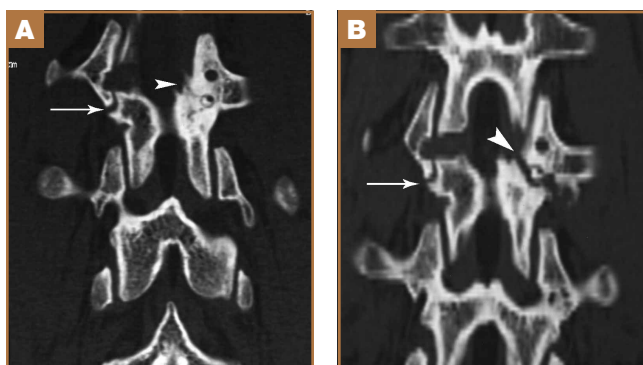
(A) Follow-up CT images 3 weeks after second RFA show minimally displaced left pars interarticularis defect (arrowhead) and unchanged right pars interarticularis defect (arrow). (B) Follow-up CT images 6 months after second RFA show nonunion of the left pars interarticularis defect (arrowhead) and unchanged right pars interarticularis defect (arrow).
